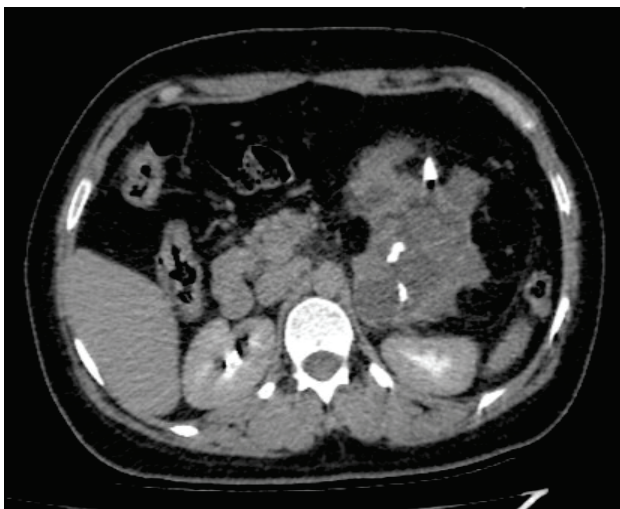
Contrast enhanced axial Computed tomography (CT) image shows well circumscribed lesion in left upper abdomen, containing areas of fluid, fat and calcifications.
